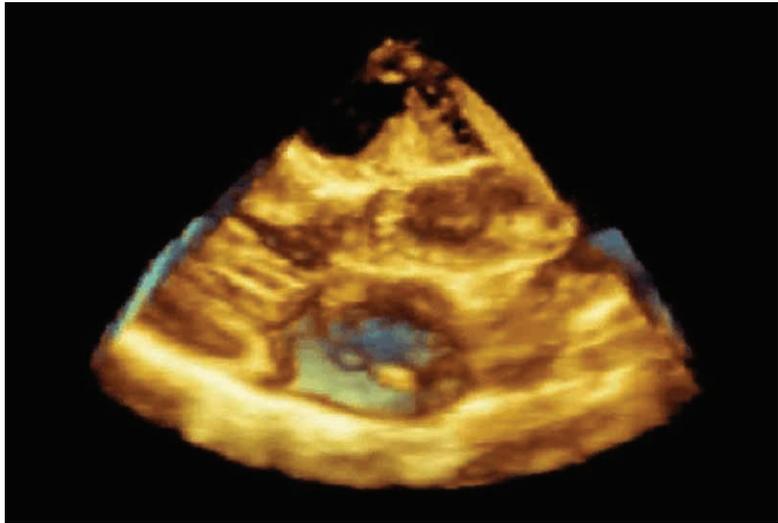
Transthoracic 3D echocardiographic view of the crossing left atrial chord without connection to the mitral valve.
